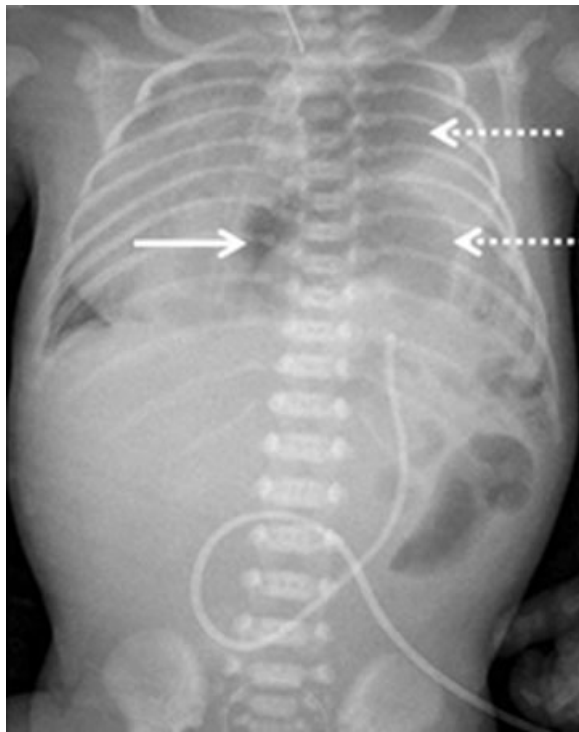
X-ray of the newborn patient, on the second day of life. X-ray shows left-sided CDH, severe dilation of intestinal loops on the left side of the chest (discontinuous arrow) and free air in the chest (full arrow). CDH, congenital diaphragmatic hernia.
